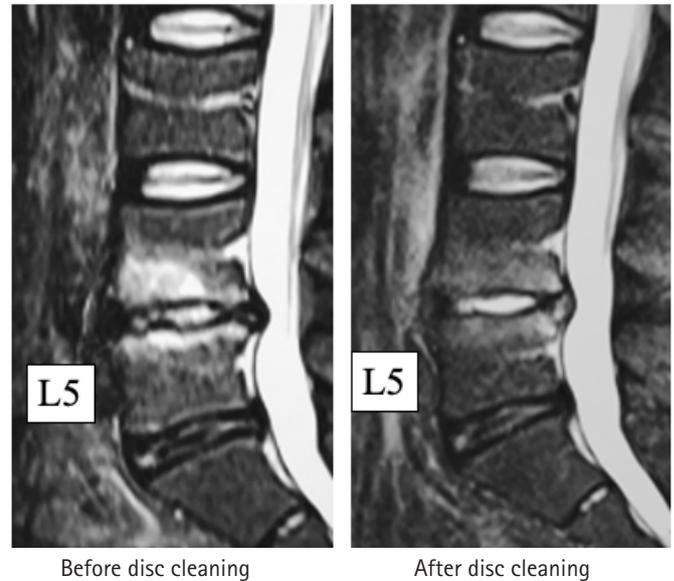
Short tau inversion recovery magnetic resonance images showing the effect of full-endoscopic disc cleaning surgery in a 37-year-old man. The image obtained before surgery clearly suggests type 1 change and another taken 2 months after surgery shows a decrease in the high signal change, indicating that the inflammation has subsided.
